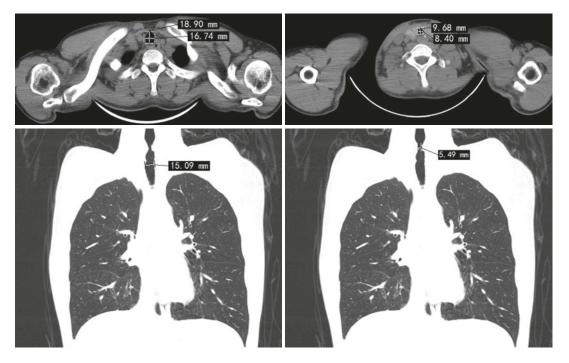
Chest CT: transverse section and MPR images of tracheal stenosis
